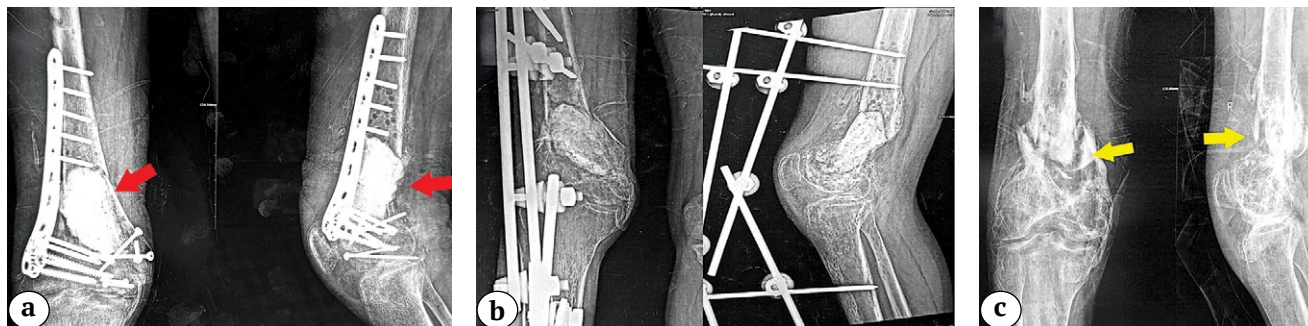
Admission X-rays of a 32-year-old male patient, who gave a history of a previous open distal femur fracture, which was treated initially with open reduction and internal fixation and got infected. Over two years, he had five surgeries (all included a sort of debridement): a – initial fixation and application of a cement spacer (red arrowheads), which failed; b – hardware was removed, and external fixation was applied; c – lastly, after reinfection, all hardware was removed, and the patient presented with an infected nonunited distal femoral fracture (yellow arrowheads) with an open sinus on the lateral aspect of the distal thigh
